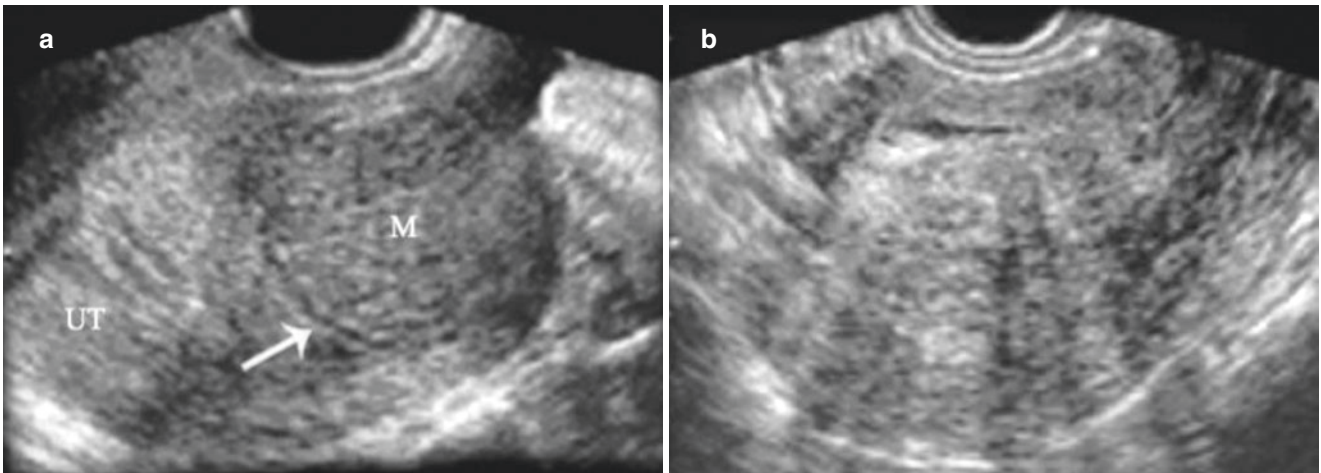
Differential diagnosis of leiomyoma and adenomyosis. (a) Sonogram shows the leiomyoma with surrounding pseudocapsule. (b) Sonogram shows the adenomyosis lesion with an indistinct boundary in the posterior wall of the uterus
